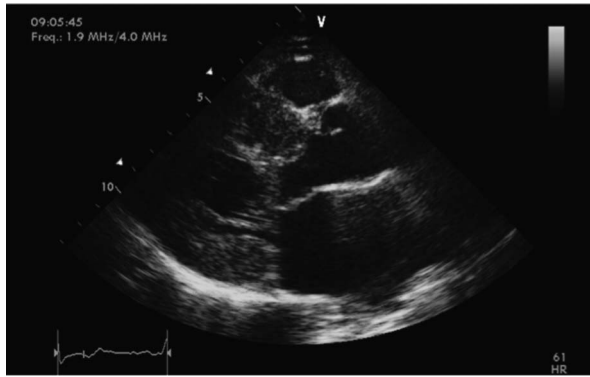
Hypertrophic cardiomyopathy. Parasternal long-axis view of a hypertrophic cardiomyopathy patient with a prominent septal hypertrophy and a moderate posterior wall hypertrophy. A systolic anterior displacement of mitral valve apparatus is observed. Myocardial texture is patchy because of myocardial fibres disarray.
